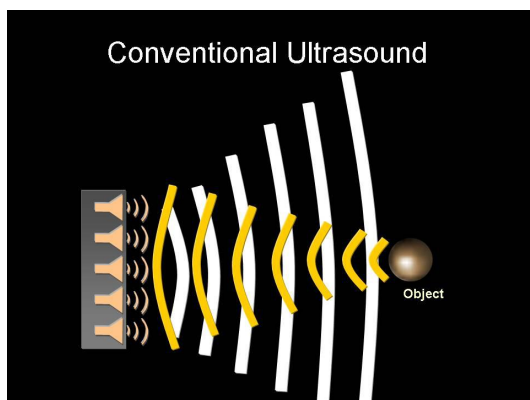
(a): In conventional ultrasound, a pulse is emitted toward a target (white wave fronts) and the subsequent reflections off the target (yellow wave fronts) are recorded by the ultrasound detector. Only those reflections that travel directly back to the source are recorded.
